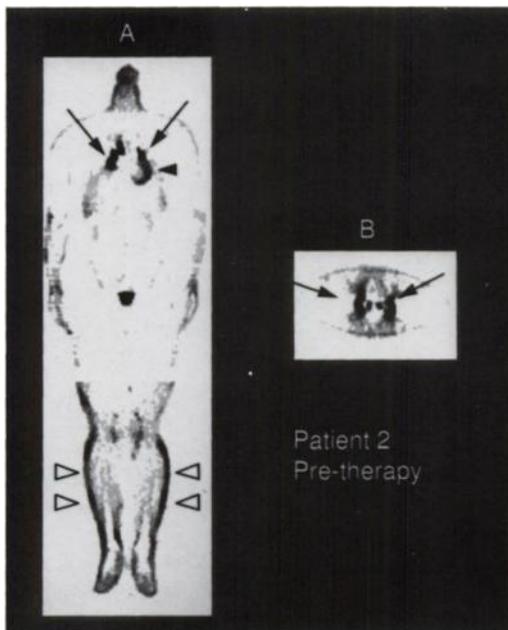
Whole-body ^{18}F FDG scan of Patient Two: (A) Coronal and (B) transaxial slice through the lung hilum showing intense ^{18}F FDG uptake by hilar lymph nodes (arrow) as well as uptake into erythema nodosum on the lower limbs (open arrowhead). The heart is indicated by the closed arrowhead.
